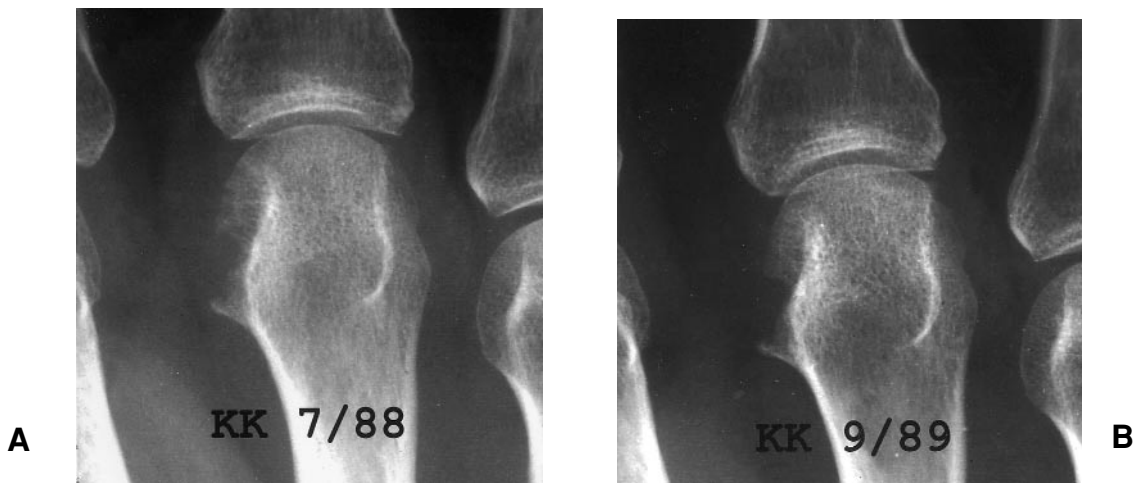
Recortication. A patient's radiographs show active erosion at the 3rd metacarpal head in July 1988 that is smoothed and recorticated in September 1989.
